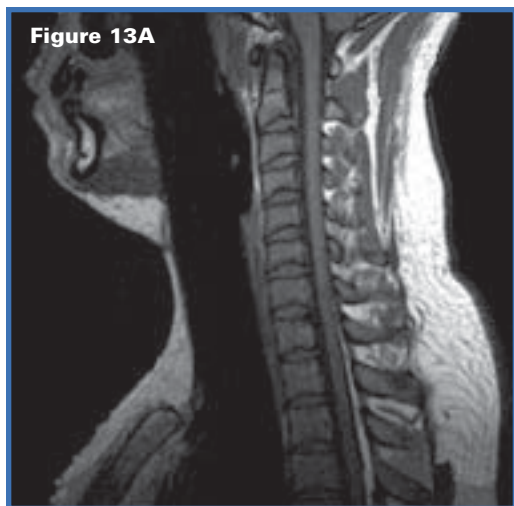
Sagittal spin-echo T1-weighted (Figure 13A) and T2-weighted (Figure 13B) images of a normal cervical spine.
